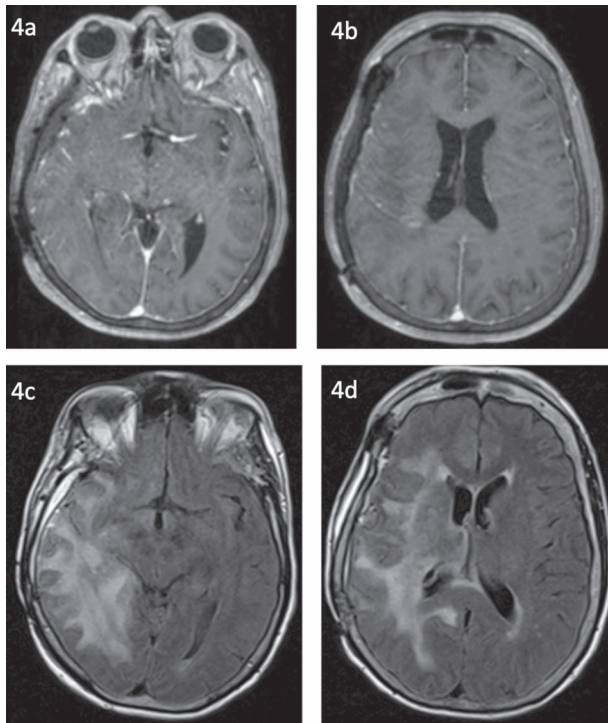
Post-surgical imaging 1 month after imaging suggestive of treatment effect. (a) Post-contrast enhanced T1-weighted MRI indicates resolution of enhancement in temporal lobe. (b) Post-contrast enhanced T1-weighted MRI indicates weakening of enhancement adjacent to the lateral ventricle. (c) FLAIR imaging reveals confluent white matter hyperintensity. (d) FLAIR imaging reveals improving mass effect on the lateral ventricle.
